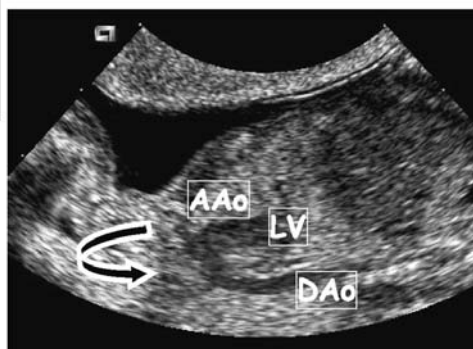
Early fetal echocardiography by 2D in a structurally normal heart. The left sagittal view of ductal and aortic arches.
